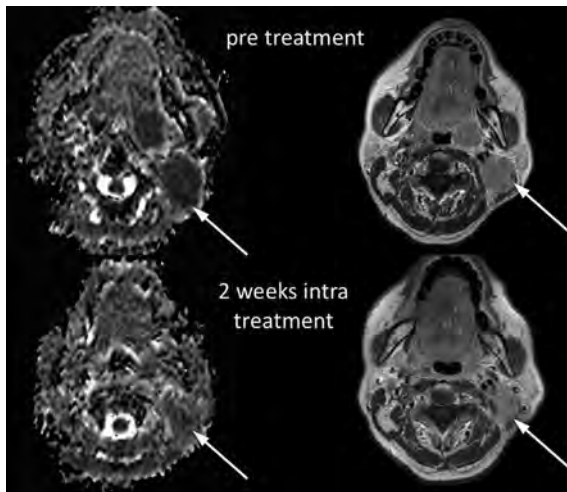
Axial DWI-MRI ADC map (*left*) and T1 W post contrast MRI in a patient with a left tonsillar SCC and metastatic IIA node pretreatment (*upper row*) and 2 weeks intra treatment with concomitant chemoradiotherapy (*lower row*). The ADC of the node increased from $1.1 \times 10^{-3} \text{ mm}^2/\text{s}$ pretreatment to $1.5 \times 10^{-3} \text{ mm}^2/\text{s}$ at 2 weeks intra treatment. This indicates increased diffusion, which favours a treatment response. There has been no locoregional recurrence as of 3 years post treatment
